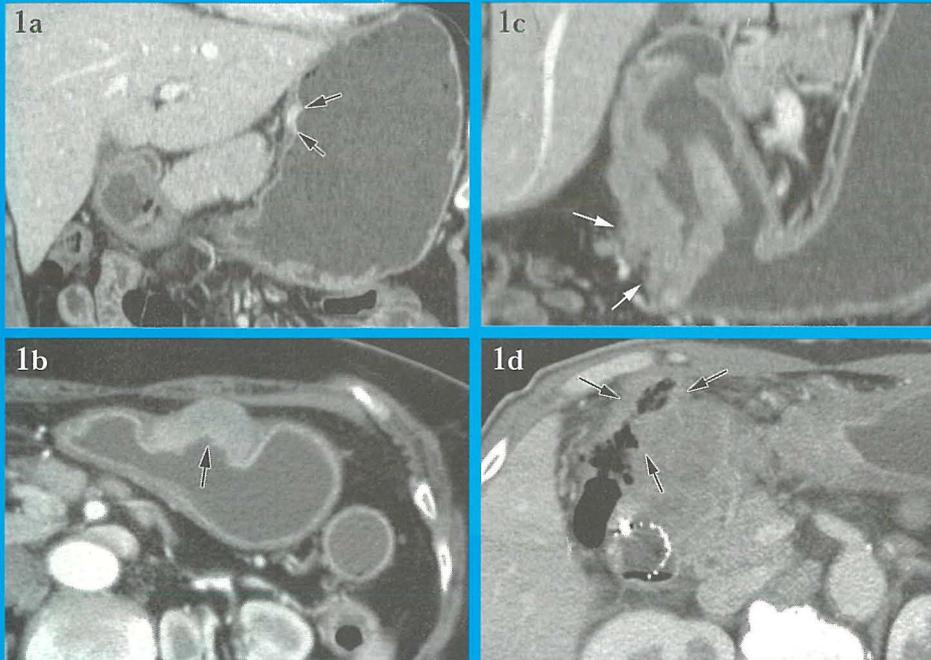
Stage T1–T4 gastric tumours. (a) Coronal reformatted image shows a stage T1 tumor (arrows) with focal nontransmural enhancement in the upper body. (b) Axial CT scan shows a stage T2 tumour (arrow), a localized, transmurally enhancing ulcerative mass without perigastric extension, in the lower body. (c) Coronal reformatted image shows a stage T3 tumour (arrows), with gross infiltration of the perigastric fat tissue in the antrum. (d) Axial CT scan shows a stage T4 tumor with invasion of the colon (arrows).
